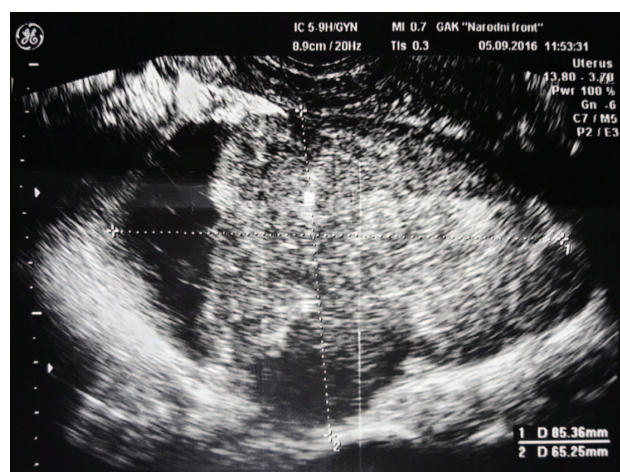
Ultrasound image of pelvic mass after chemotherapy revealed left ovary located immediately against the tumefaction (the same as the initial finding).
